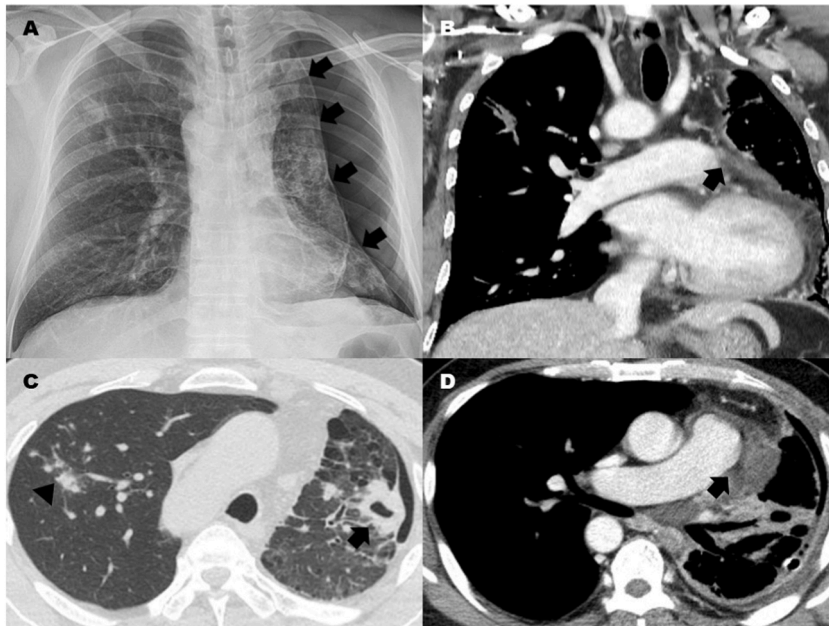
Chest radiography and computed tomography images of 46 year-old man with dyspnea
